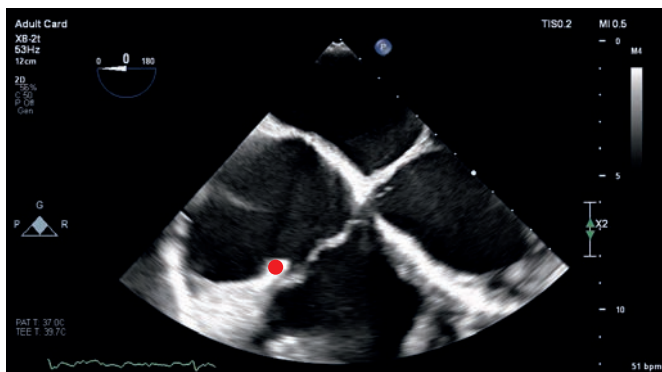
Transoesophageal echocardiography (TOE) image demonstrating a prominent ridge along the posterolateral right atrial wall (red dot) consistent with a crista terminalis. The structure is fixed and non-mobile, with no features suggestive of thrombus or mass.
